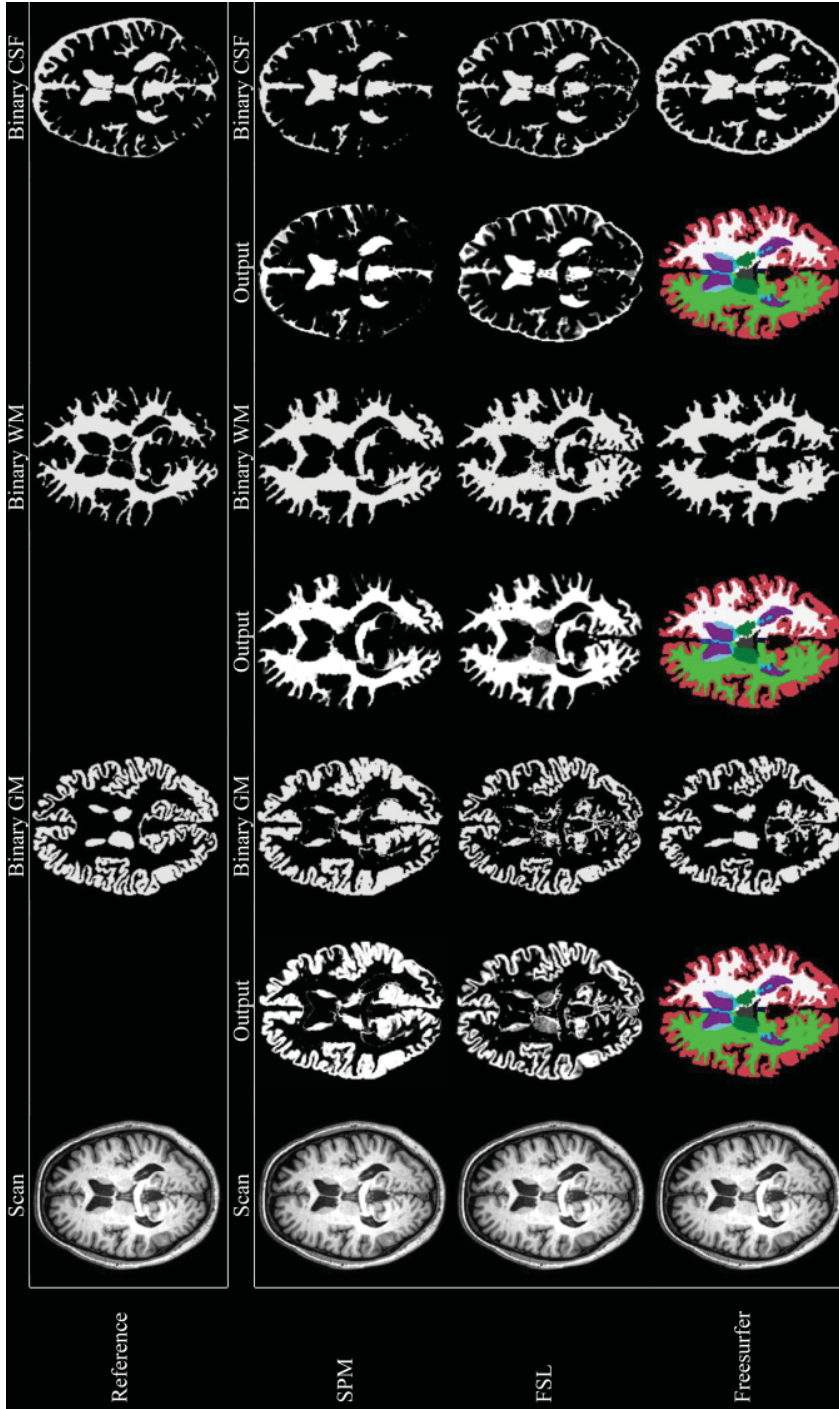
Reference measurements and automated brain volume measurements at 3T. Examples of the performed measurements for the accuracy analysis for one subject on 3T MRI. Individual measurements are shown in native space (probabilistic for SPM and FSL, and binary for Freesurfer). Also, binary measurements for each tissue compartment are shown for all methods (using a threshold of 0.5 in case of probabilistic segmentation). GM, gray matter; WM, white matter; CSF, cerebrospinal fluid.
